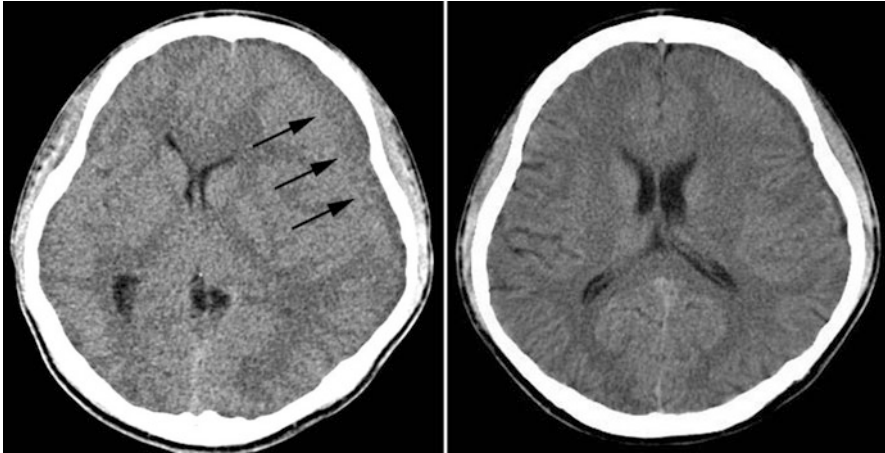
Clinically occult intracranial injury. 15-year-old who complained of an ongoing headache for the preceding few days. There was no specific history of trauma or injury, although the patient was a soccer player and had participated in a soccer game 5 days previously. On physical examination, no focal neurological deficits or clinical signs of head injury were found; however, a CT was obtained due to the patient's complaint of ongoing headache. A noncontrast CT scan demonstrated an isodense subdural hematoma (SDH) (*black arrows*) indicating it was subacute in timing (see text below). The SDH had mass effect on the adjacent brain resulting in shift of the brain to the right. Also notice the displacement of the gray matter-white matter junction away from the inner table of the skull. A repeat CT scan following surgical drainage of the SDH showed resolution of the previously seen midline shift and a more symmetrical appearance of the lateral ventricles
